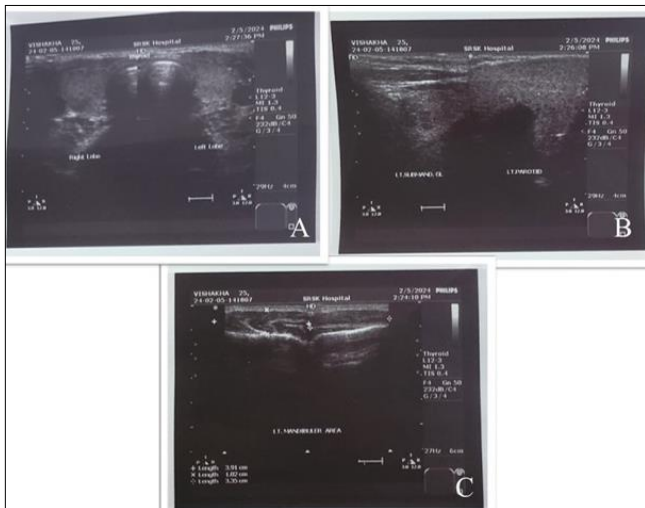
Ultrasonographic images revealing a hypochoic mass with echogenic thick bands
